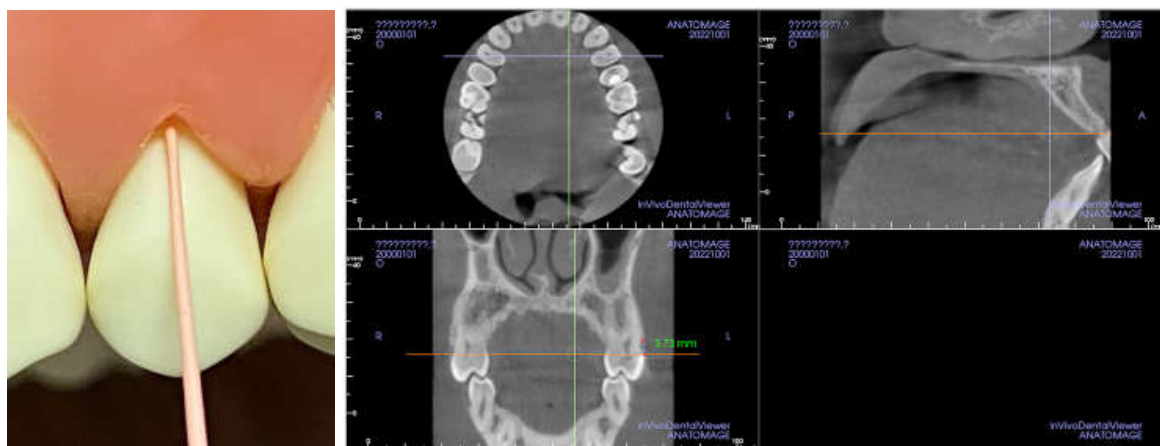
Non-invasive visual method for determining BWP using cone beam computed tomography (CBCT) (according to A. S. Rubnikovich, V. A. Solomevich, 2020)
